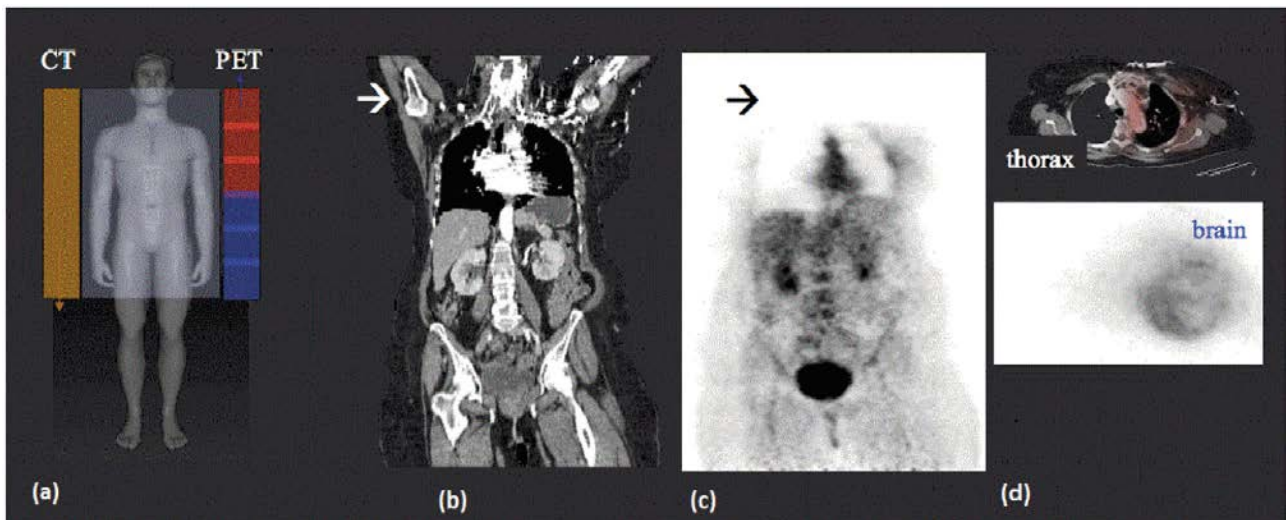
Whole body FDG-PET/CT study of a mentally retarded patient. (a) Scan sequence for CT and multi-bed emission scan; (b) Contrast enhanced CT; (c) AC-PET with missing information in the head/neck region. Here, the patient moved out of the PET/CT before the entire examination was finished (it should be noted that the emission scan range in (a) was not covered during the examination). The patient rested for a moment half way, yielding a superposition of brain and thoracic uptake patterns (d). AC: attenuation corrected.
